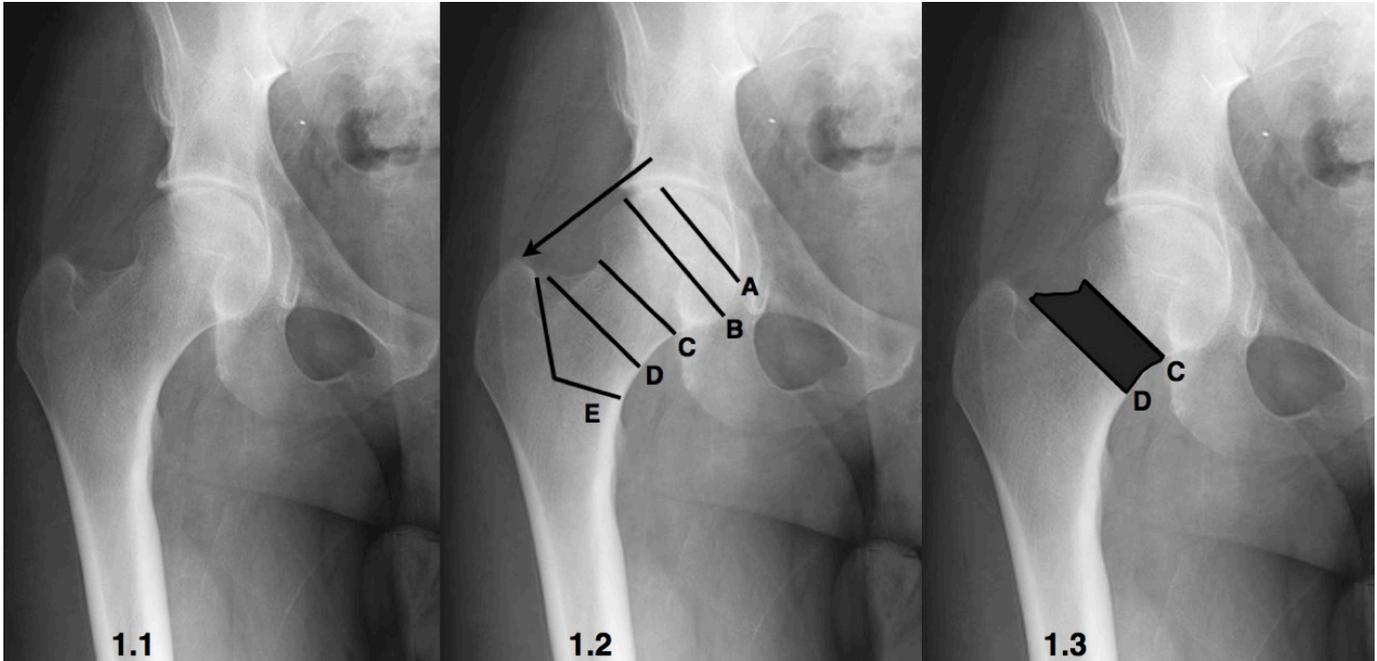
AP Radiograph demonstrating a healthy native right hip joint.
